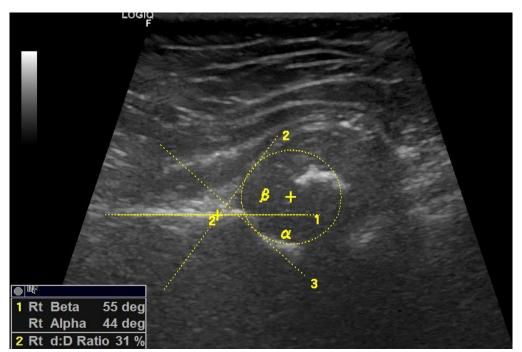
Ultrasound evaluation of 2 months male with eccentric hip dislocation.
